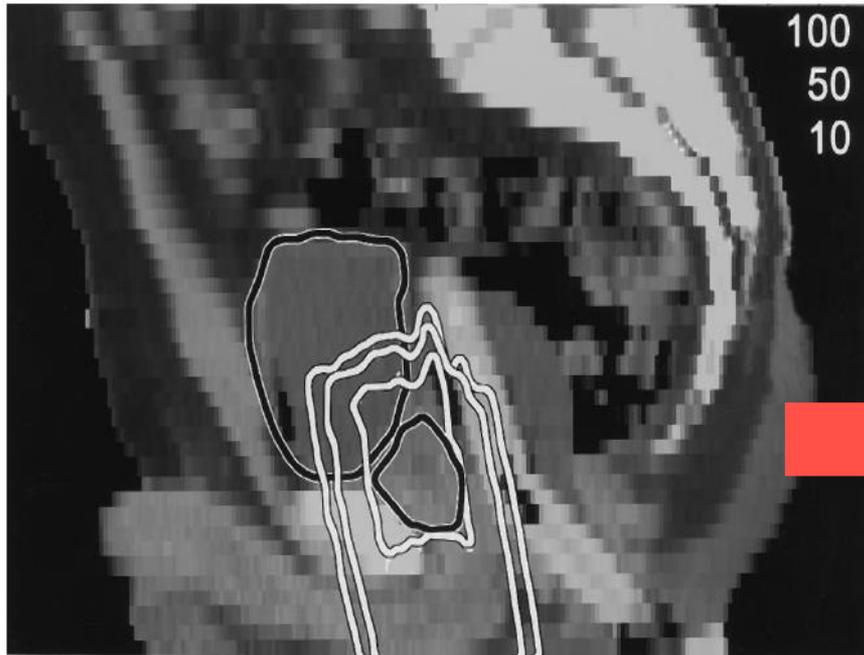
Sagittal CT reconstruction shows perineal proton boost technique and how beam high dose region incorporates prostate, prostatic urethra and bladder neck.
